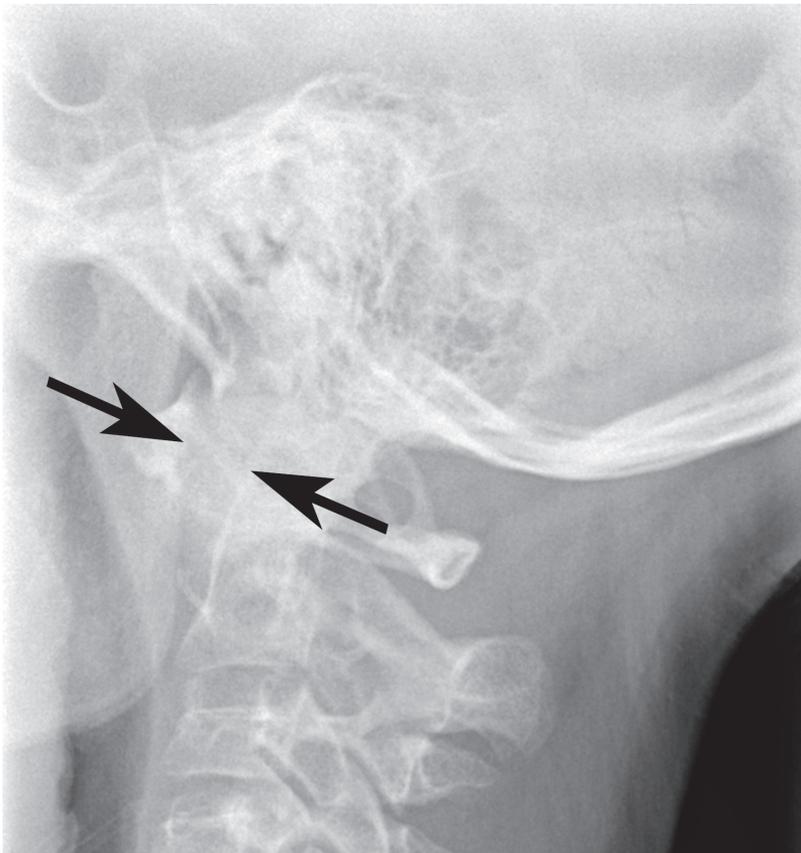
Radiograph demonstrated severe C1–C2 subluxation with increased distance between the anterior arch of C1 and the anterior cortex of the odontoid (arrows).
